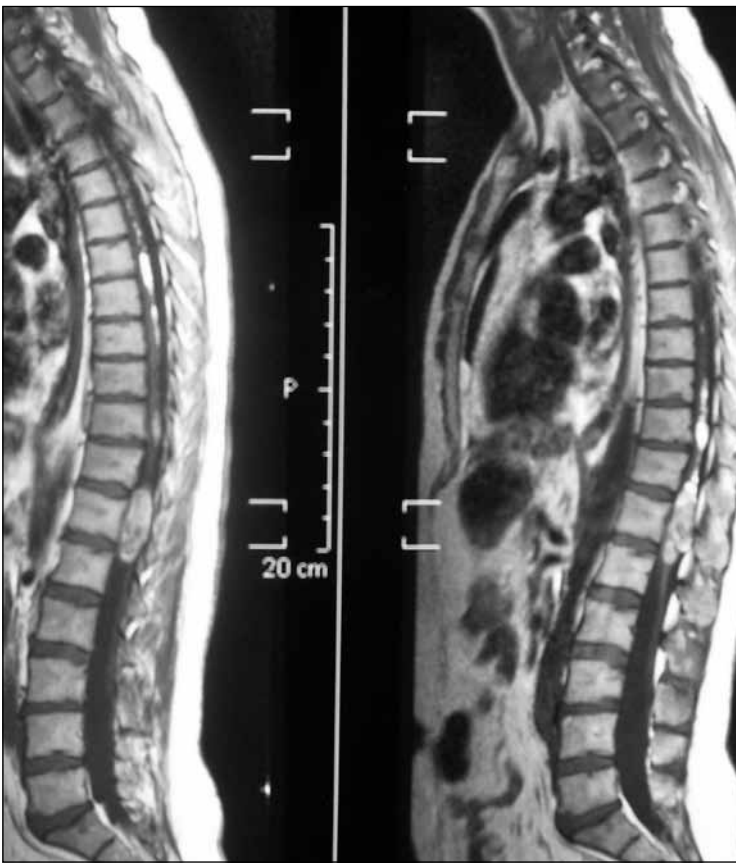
Sagittal whole spine non-contrast T-1 MR images showing a lobulated conus medullaris mass with hyperintense fat content in the enlarged syrinx cavity.
